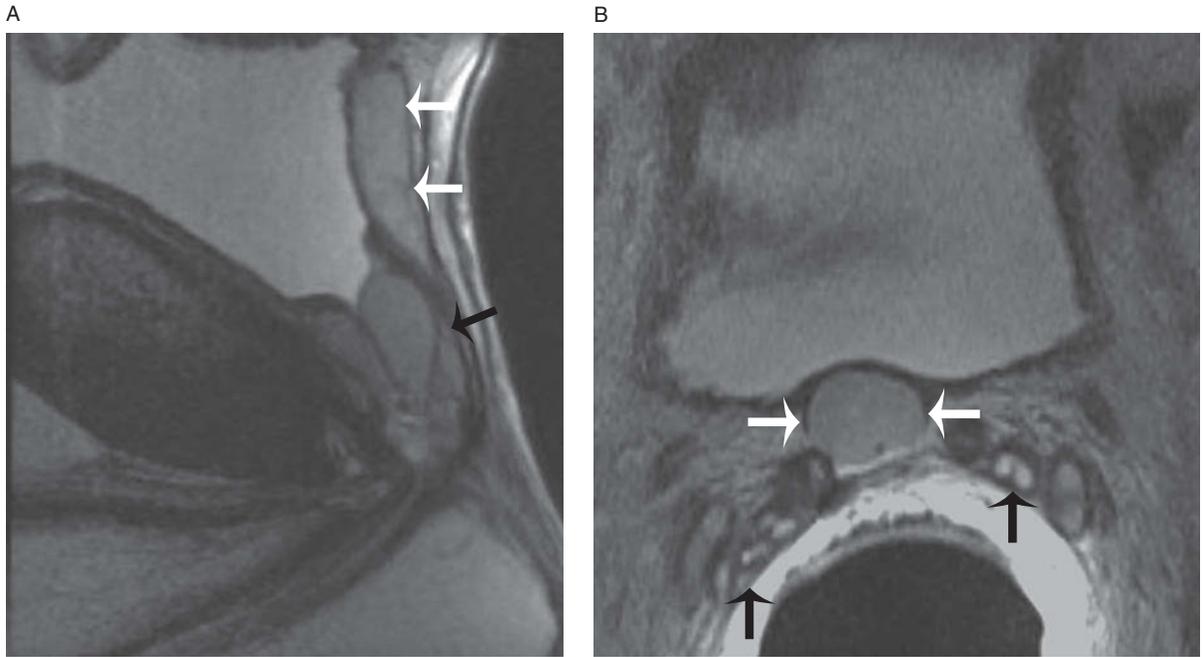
Müllerian duct cyst in a 62-year-old male status post prostatectomy. Sagittal T2-weighted image (A) shows an elongated high T2 signal intensity structure extending posterior to the bladder (white arrows). Also note intermediate signal intensity material at the bladder base (black arrow) due to prior collagen injections for urinary incontinence status post prostatectomy. Axial T2-weighted image (B) further demonstrates that the high T2 signal intensity structure posterior to the bladder is midline. The midline location and extension posterior to the bladder of this cystic structure is characteristic of a müllerian duct cyst. Also note residual seminal vesicles on the axial image (black arrows).
